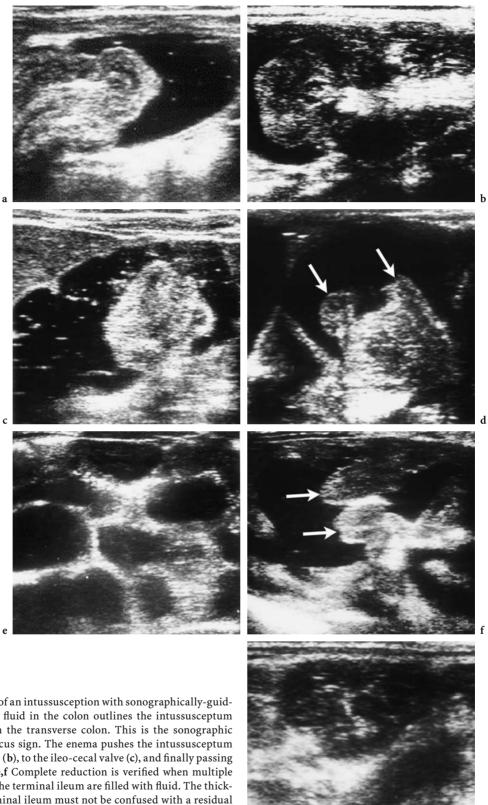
Reduction of an intussusception with sonographically-guided saline enema. a The fluid in the colon outlines the intussusceptum in its initial location in the transverse colon. This is the sonographic equivalent of the meniscus sign. The enema pushes the intussusceptum into the ascending colon (b), to the ileo-cecal valve (c), and finally passing through the valve (d). e,f Complete reduction is verified when multiple bowel loops, including the terminal ileum are filled with fluid. The thick-ened and collapsed terminal ileum must not be confused with a residual intussusception. The ileo-cecal valve (*arrows*) appears thickened on the longitudinal scan. g On the axial image, the collapsed ileum produces the "mercedes-benz" sign seen: \Im [From DEL POZO (1999)]
